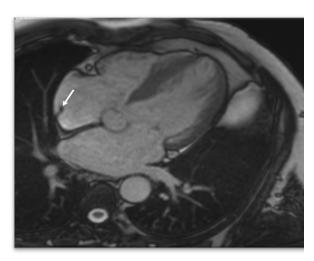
A 46 years old man who has PCT 13 mm on the right posterolateral atrial wall had a preliminary diagnosis of a mass in the posterior wall of the right atrium in echocardiography examination.
